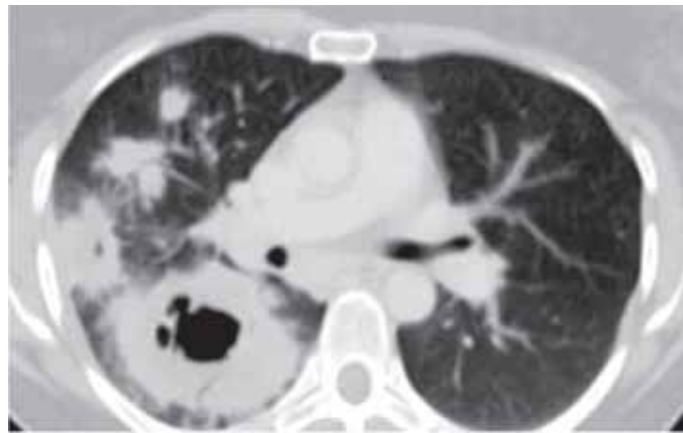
CT Scan showing posteriorly cavitory lesion on the right side
